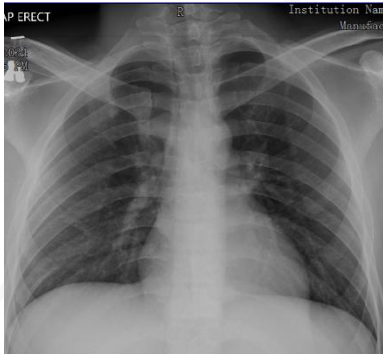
Chest X-ray prior to discharge
